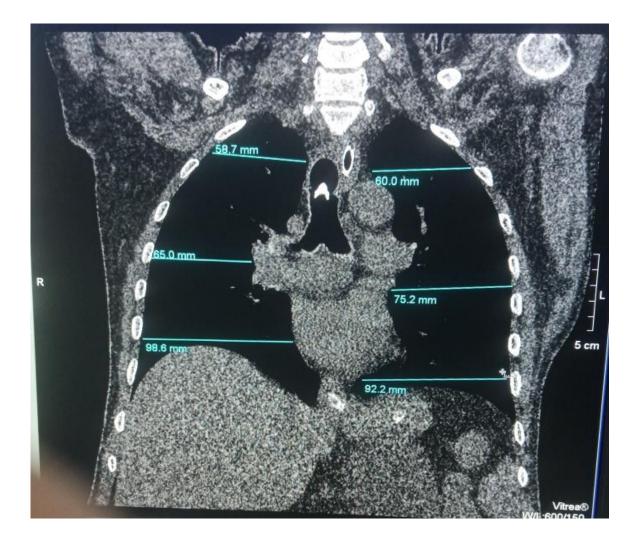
Measurement of lungs on chest CT scan (FromResearch)
